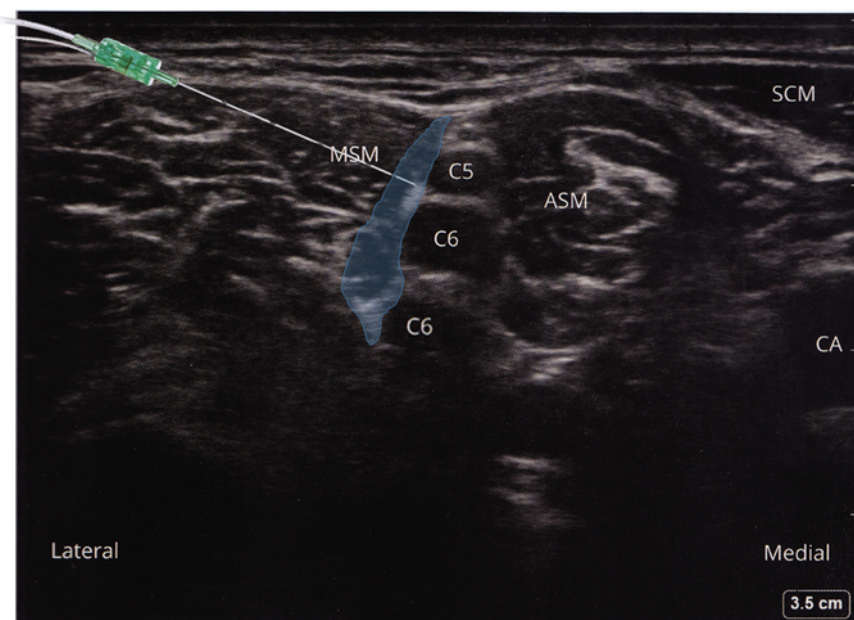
Sonographic appearance of the brachial plexus at the interscalene groove. Needle shall be inserted from lateral to medial, with local anesthetic 10–15 ml deposited in between C5 and C6 nerve roots (without the need for the needle tip in contact the nerve roots). Ultrasound image depicting the “stoplight” sign, referring to 3 hypoechoic structures found between the anterior and middle scalene muscles. ASM, anterior scalene muscle; CA, carotid artery; MSM, middle scalene muscle; SCM, sternocleidomastoid muscle. The figure has been modified with permission [4].
